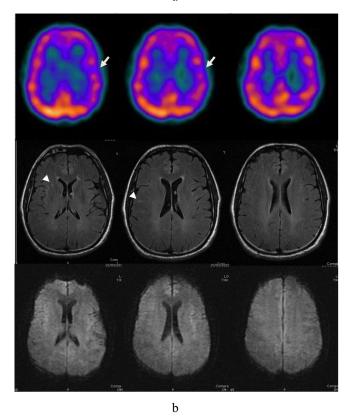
Comparison of brain SPECT and MRI findings in a 37yo male (first study). a: mild perfusion defect of right fronto-parietal cortex (arrows) at SPECT. MRI FLAIR sequence shows only minimal unspecific gliotic lesions (arrowheads) close to the hypoperfused area detected by SPECT. b: moderate perfusion defect of right temporal lobe pole at SPECT study. No focal alterations detected with MRI.
